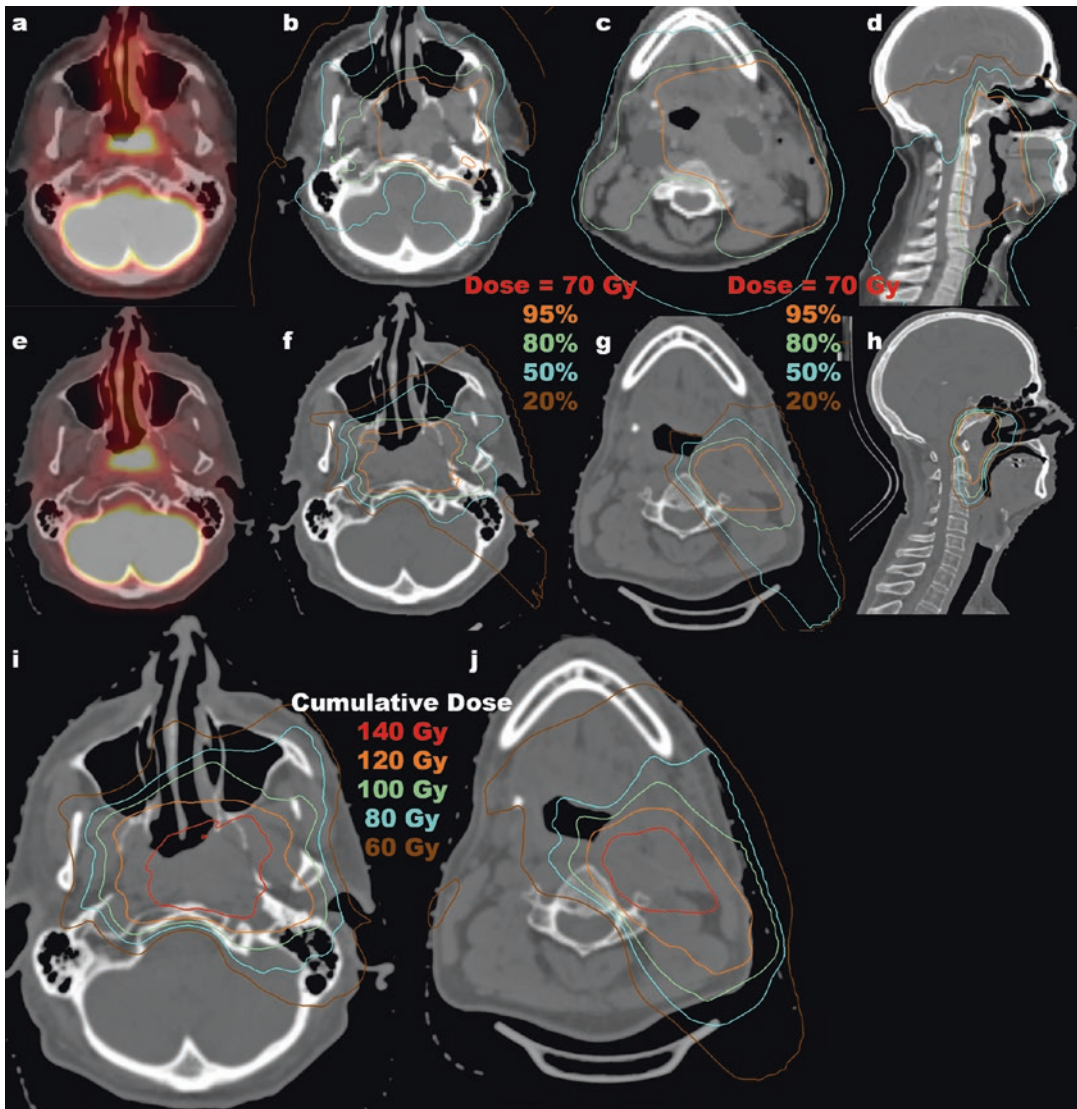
A 48-year-old man was reirradiated for recurrent nasopharyngeal squamous cell carcinoma. He presented with headaches, left-sided otalgia, and a serous otitis media and was found to have a nasopharyngeal mass (a) extending down the oropharyngeal wall to the level of the larynx with associated ipsilateral necrotic neck adenopathy. His pathology was negative for p16. He was treated with tomotherapy to 70 Gy in 35 fractions (b–d) with three cycles of 100 mg/m² cisplatin chemotherapy (third cycle dose reduced). He had profound xerostomia and dysphagia with over 70 lb of weight loss and remained gastrostomy tube dependent 9 months after radiation. Follow-up PET/CT showed resolution of hypermetabolic uptake but with residual centrally necrotic nodal adenopathy. Six months after radiation, an FNA of the nodal mass confirmed residual viable neck disease and a repeat PET/CT 7 months after radiation showed recurrent disease in the nasopharynx (e), biopsy proven. Given the short time
